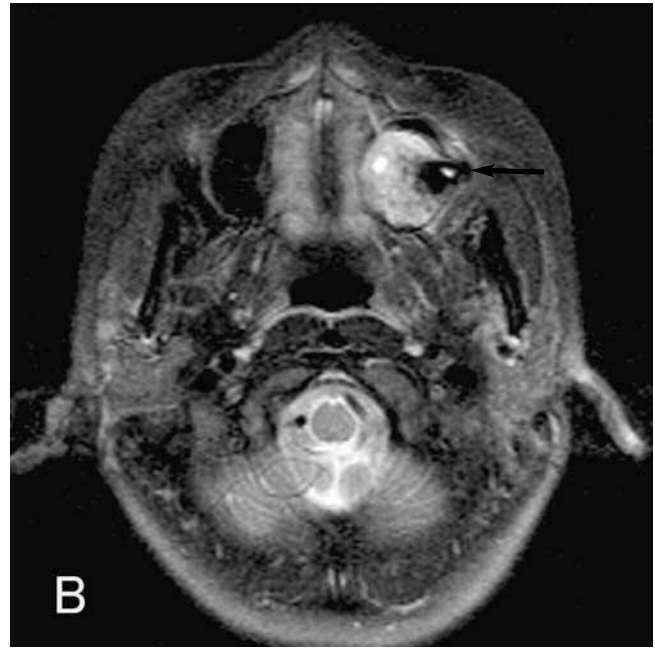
MR images show a lesion in the alveolar bone of the left maxilla (arrow).
